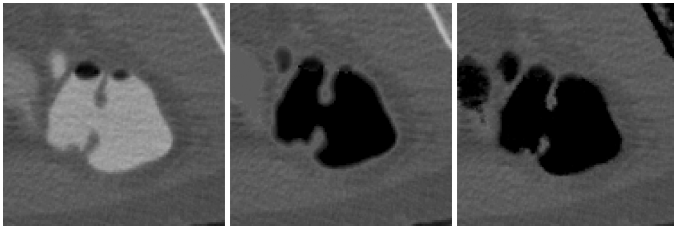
TM removal to recover buried soft tissues. (left) A zoomed-in view of a small region in a slice of a CT scan. (middle) The result after removal of the TMs. (right) The result of our previous MAP-EM algorithm without the mixture modeling, shown for comparison purposes.
